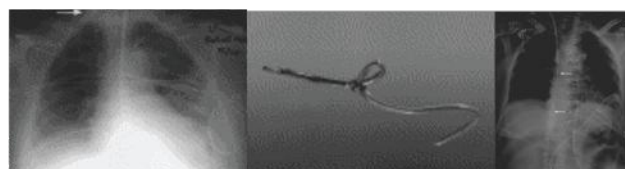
A. Chest X-ray showing knotted catheter in the superior vena cava B. Catheter showing the knot following successful surgical removal. C. X-ray chest shows malposition of a Swan-Ganz catheter (arrows) in the inferior vena cava.
